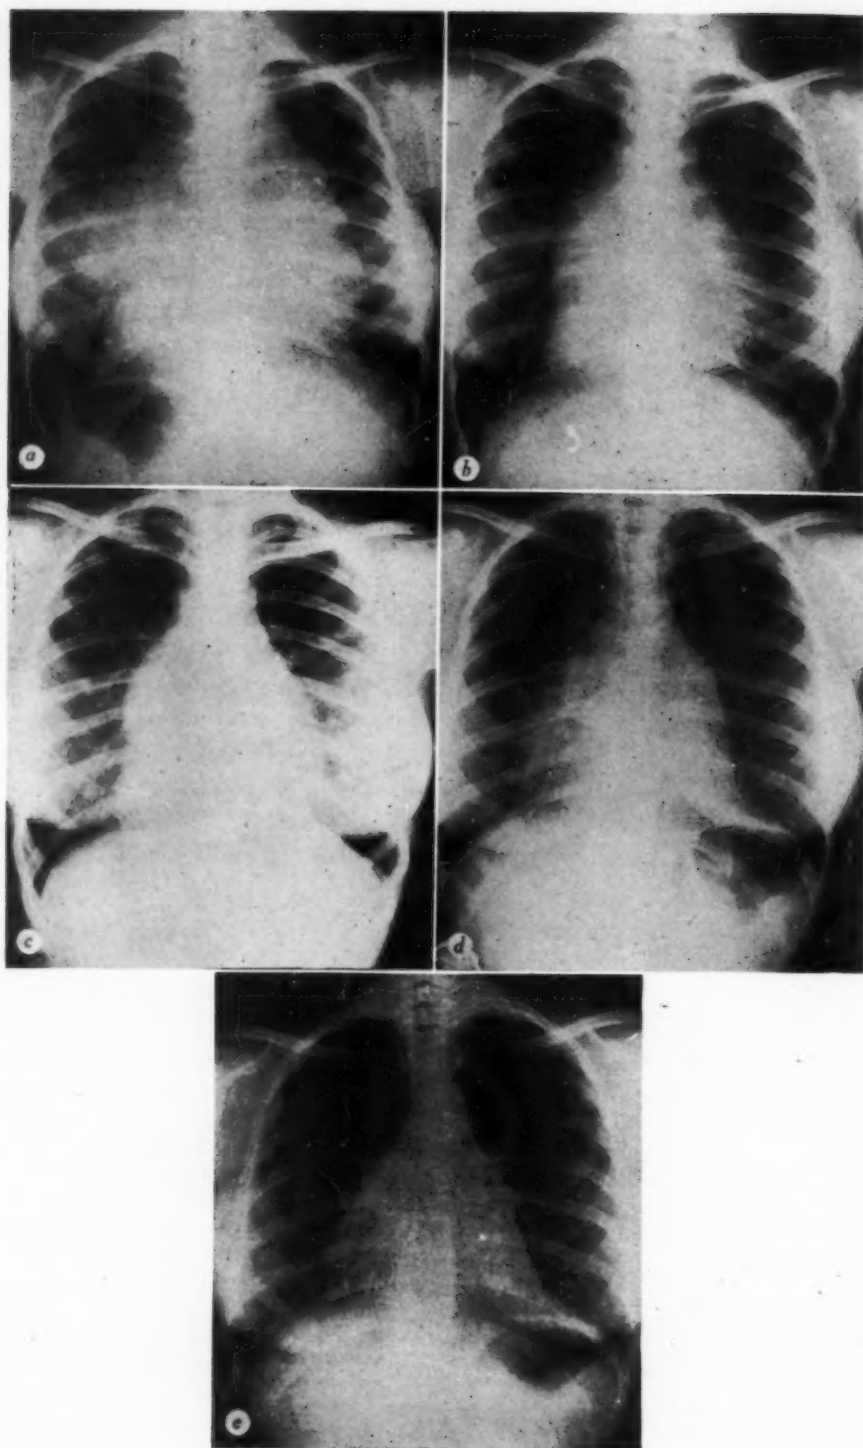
Roentgenogram made on January 31, 1945. It shows some widening of the upper part of the mediastinal shadow and an unusual lesion in the posterior peripheral portion of the parenchyma of the right lung, at the level of the sixth and seventh ribs. This lesion was thought to be tuberculosis. The patient's head, face and neck had become engorged (puffy) and cyanotic, the superficial veins of the anterior wall of the chest and abdomen had become prominent, he had become progressively weaker and his weight had diminished 14 pounds (6.4 kg.) in six weeks. Enlarged lymph nodes were present in both sides of the neck and in both armpits.—*Fig. 1b:* Roentgenogram made on March 12, 1945, after a single course of roentgen treatment. It shows considerable reduction in the width of the mediastinal shadow and in the area of interlobar infiltration in the right lung. The venous engorgement and cyanosis of the head, face and neck had disappeared and the patient felt and appeared to be much better.
